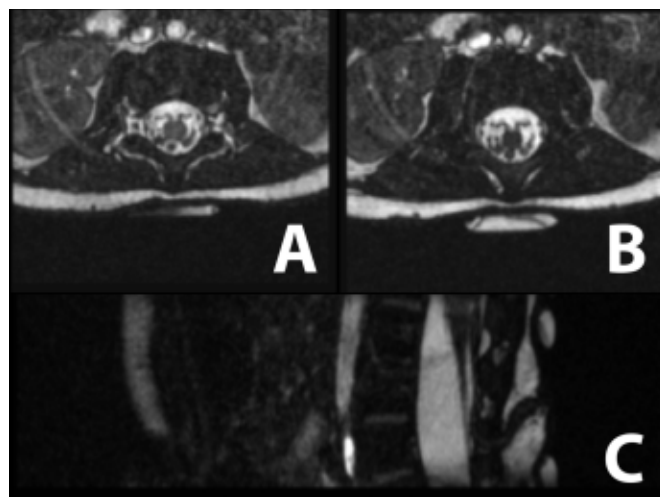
Axial T2 MRI view showing intradural extension of DST that originated at L5-L6 level (A) and tethering of conus by DST (B). Sagittal MRI view also demonstrated intradural extension of DST and termination at the tip of conus, which was low-lying at the inferior end plate of L3 (C).
